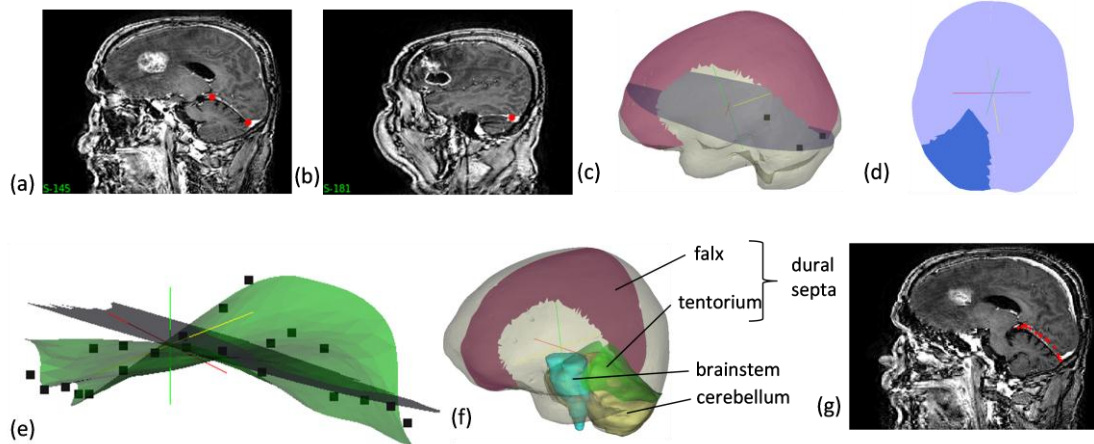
Procedure for tentorium segmentation. (a) and (b) show the selection of three points used for clipping a plane in the mesh, (c) shows the clipped plane (with those three points) overlaid with the mesh and the falx, (d) shows the clipped plane segmented into an approximate tentorium shaped structure and (e) shows the segmented plane with the final tentorium surface created by morphing the plane in (d) using a thin plate spline algorithm. The points on the surface are the target points used to drive the thin plate spline algorithm. (f) shows the mesh overlaid with the segmented falx and the tentorium surfaces. The segmented brainstem (in blue) and cerebellum (in yellow) are shown for reference, were not modeled separately. (g) is the sagittal MRI slices overlaid with the red points of the tentorium surface. A good overlap of the points and the hyperintense region indicate the quality of segmentation.
